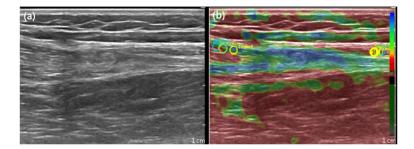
Ultrasound image (A) and Elasto image (B) of foream after ultrasound therapy. ROI 1-cm away from anterior compartment of forearm to brachioradialis muscle of the upper extremity.
